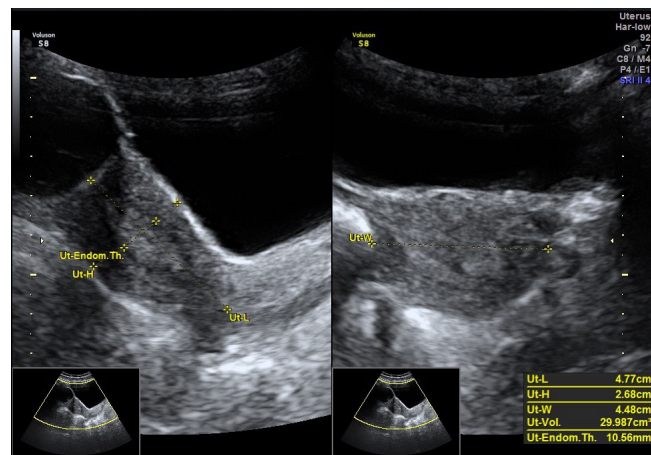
The uterine sonogram revealed a normal appearance.
